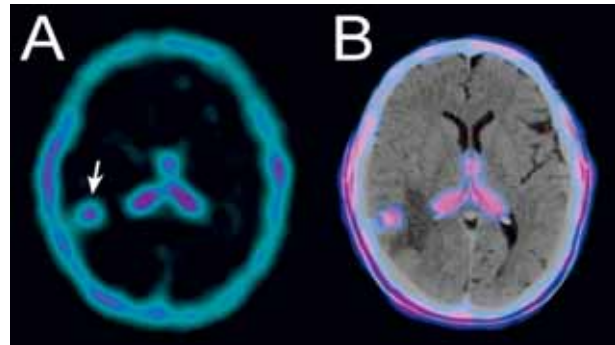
A : ^{99m}Tc -TF brain SPECT shows a lesion with strong tracer uptake in the right temporal lobe ; B : ^{99m}Tc -TF brain SPECT superimposed on CT image.
